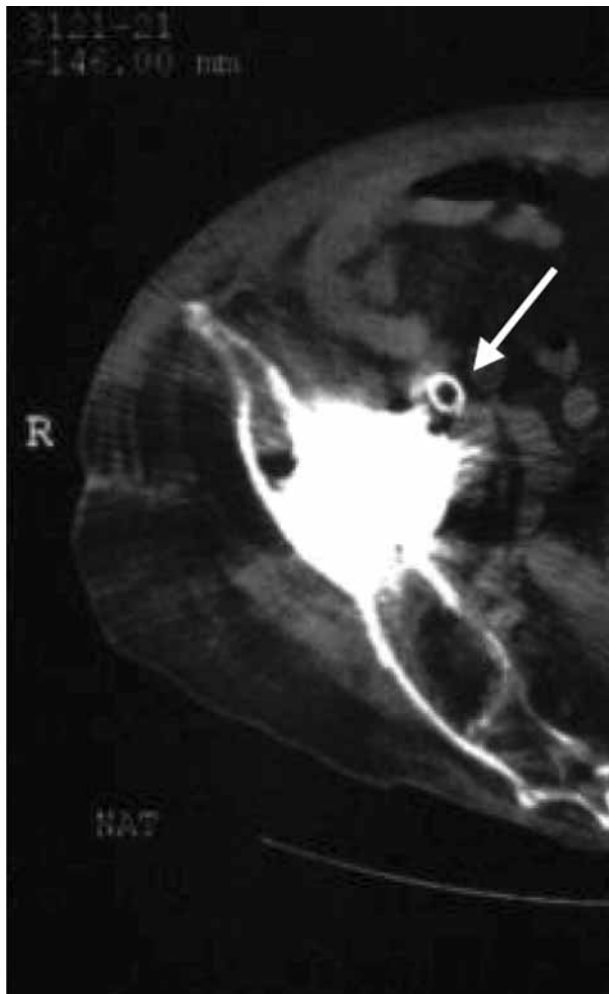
Transversal CT-scan of the right pelvis, two days after intervention : Correct position of the stent (→) and no increase in size of the haematoma.
